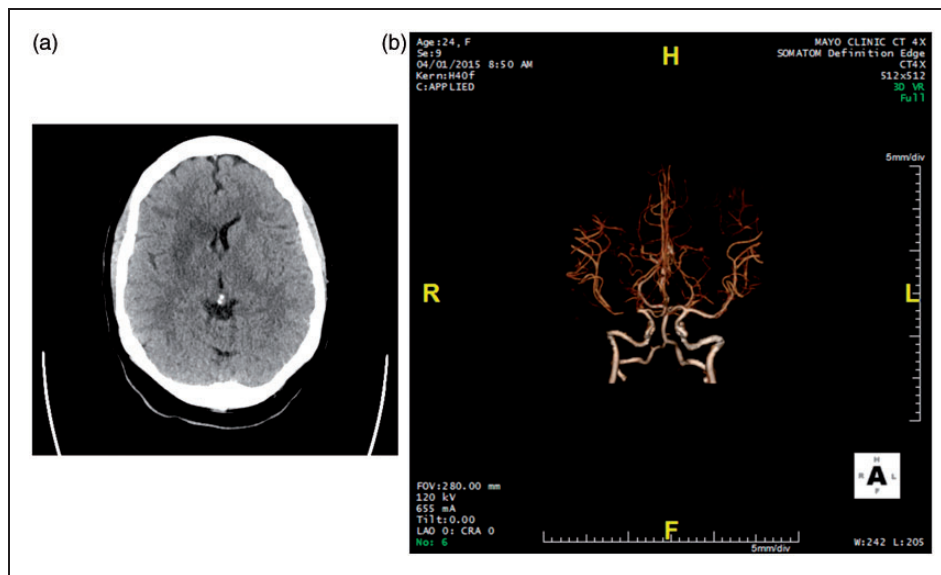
(a) Computed tomography (CT) obtained following onset of symptoms revealing hypodensity. (b) CT angiogram obtained following onset of symptoms revealing a right M1 occlusion.
